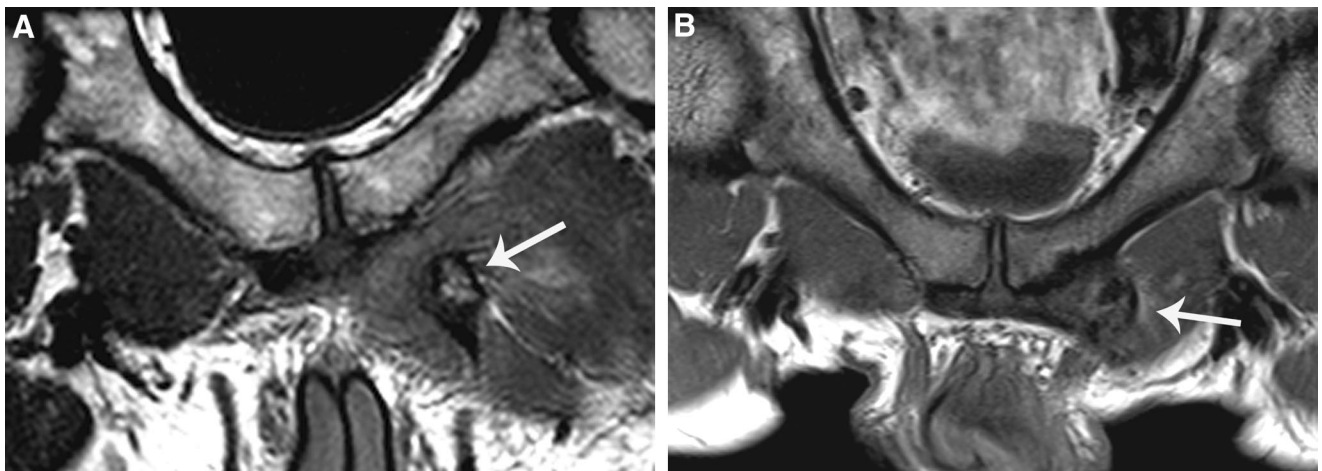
MRI of adductor variants: Proton density weighted MR image in a professional soccer player with acute left-sided groin pain (A) and long history of osteitis pubis shows an osseous avulsion of the pubic tubercle (arrow) and caudal retraction with entire proximal adductor longus. Similar proton density weighted image in a 46-year-old marathon runner (B) shows a more indolent injury at the adductor longus origin with enlargement, ill definition, and hypointensity (arrow) indicating hydroxyapatite deposition disease ("calcific tendinosis").
